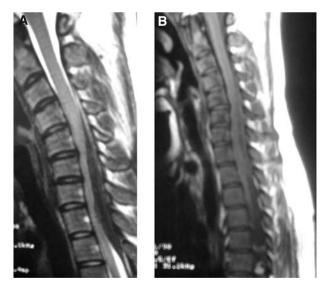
A T2-weighted sagittal MRI. Biconvex cervical epidural hypointense TB abscess. B T1-weighted sagittal MRI with gadolinium. The same lesion in iso signal without enhancement. The patient underwent surgery with C5-T2 laminectomy and excision of the intrarachidian TB mass
